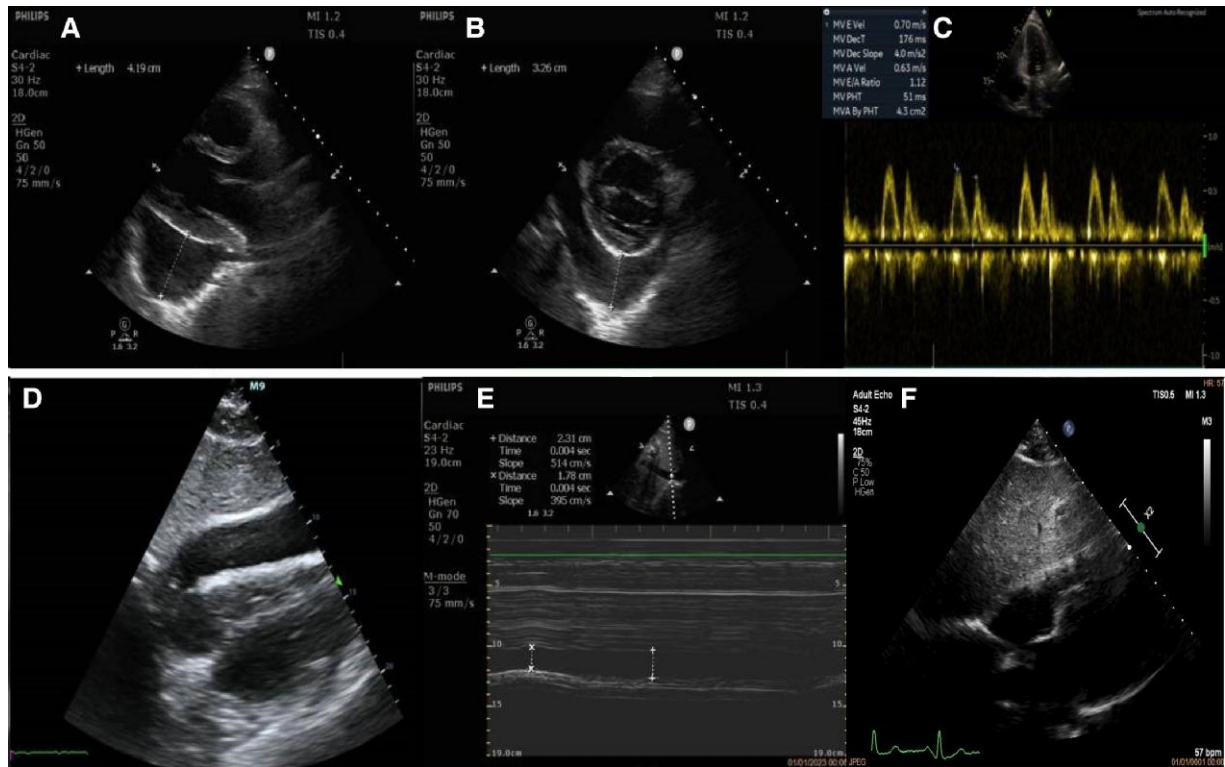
(A) Parasternal long axis view. Pericardial effusion diameter is 4.19 cm behind the inferolateral wall of the left ventricle. (B) Parasternal short axis. Pericardial effusion diameter is 3.26 cm behind the inferior wall of the left ventricle. (C) Transmittal inflow pattern. $E/A = 1.12$ with normal filling pressures. (D) Subxiphoid view. Pericardial effusion diameter is 2.6 cm in the space adjacent to the right ventricle. (E) Inferior vena cava dilatation with reduced inspiratory decrease. (F) Subxiphoid view after pericardial window, without pericardial fluid at end diastole.
